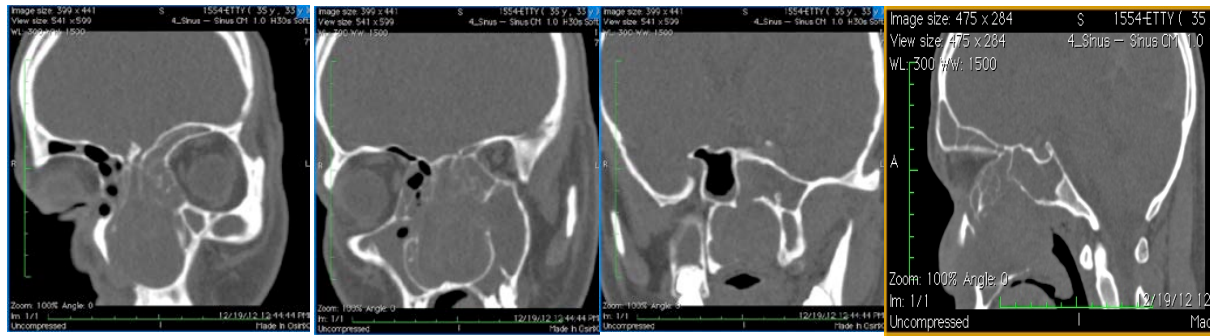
Paranasal CT Scan of the patient with Woakes Syndrome
